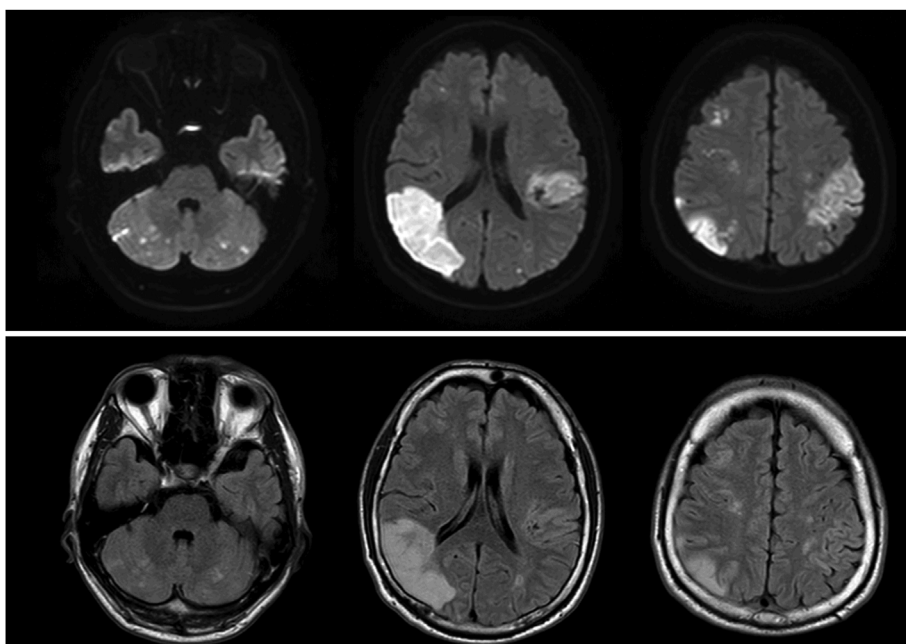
Magnetic resonance imaging (MRI) of the brain. Diffusion-weighted images (DWI) (upper). Fluid-attenuated inversion recovery images (FLAIR) (lower). Non-segmental multiple cerebral infarctions of various sizes are revealed in the cerebellum, cerebral cortex, and the cerebral white matter. Because these infarctions appeared as high-density areas using DWI and as iso- or high-density areas using FLAIR, these were ultra-acute infarctions.
